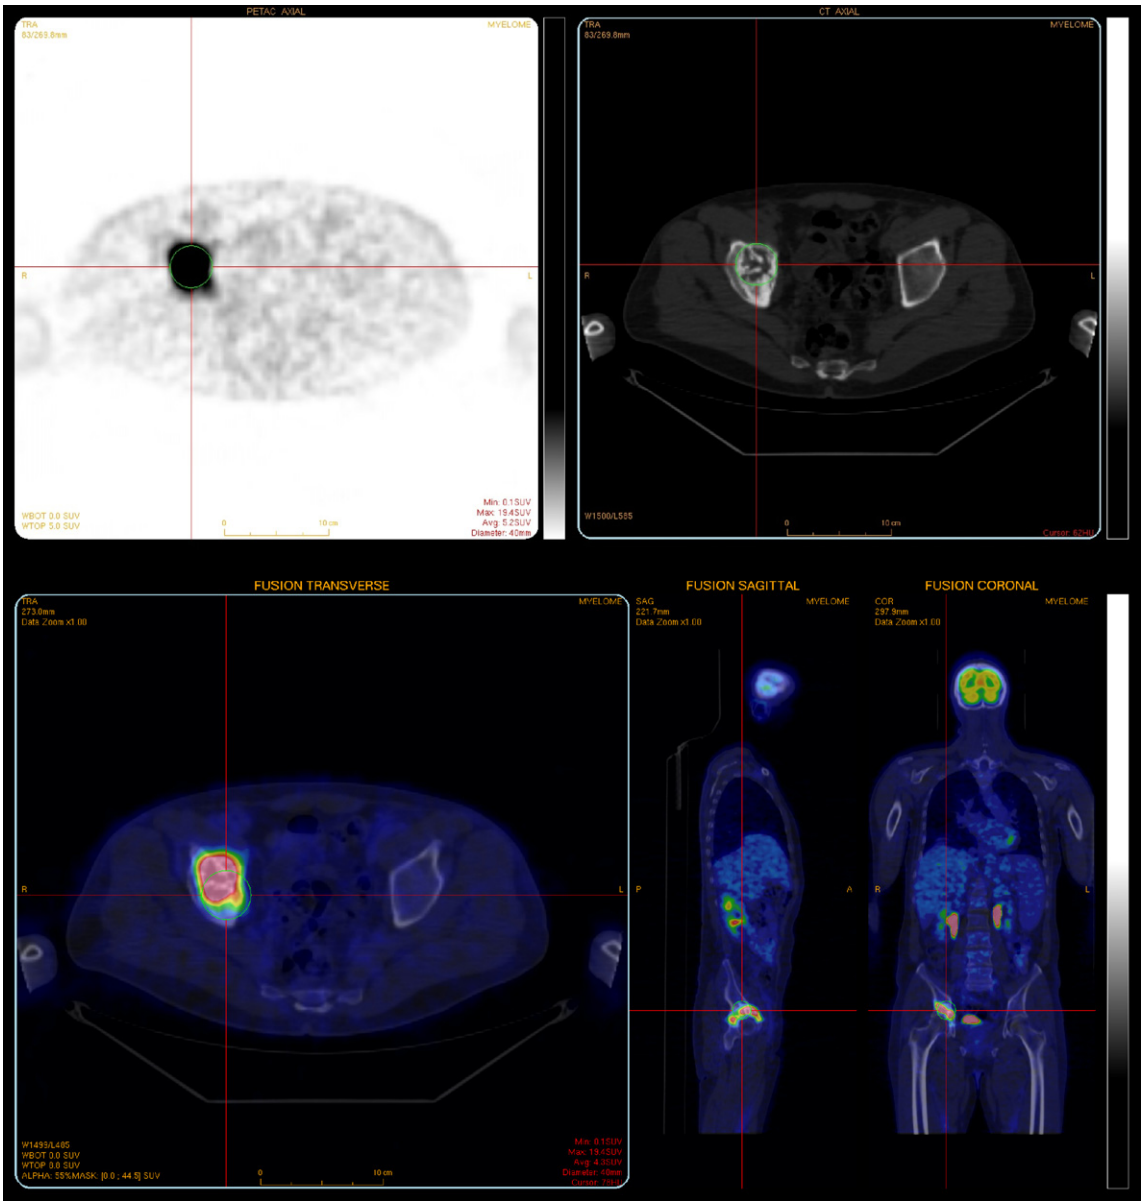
Case 1 18-FDG PET/CT showing intense uptake of a mixed lytic and sclerotic lesion located on the right acetabulum.
